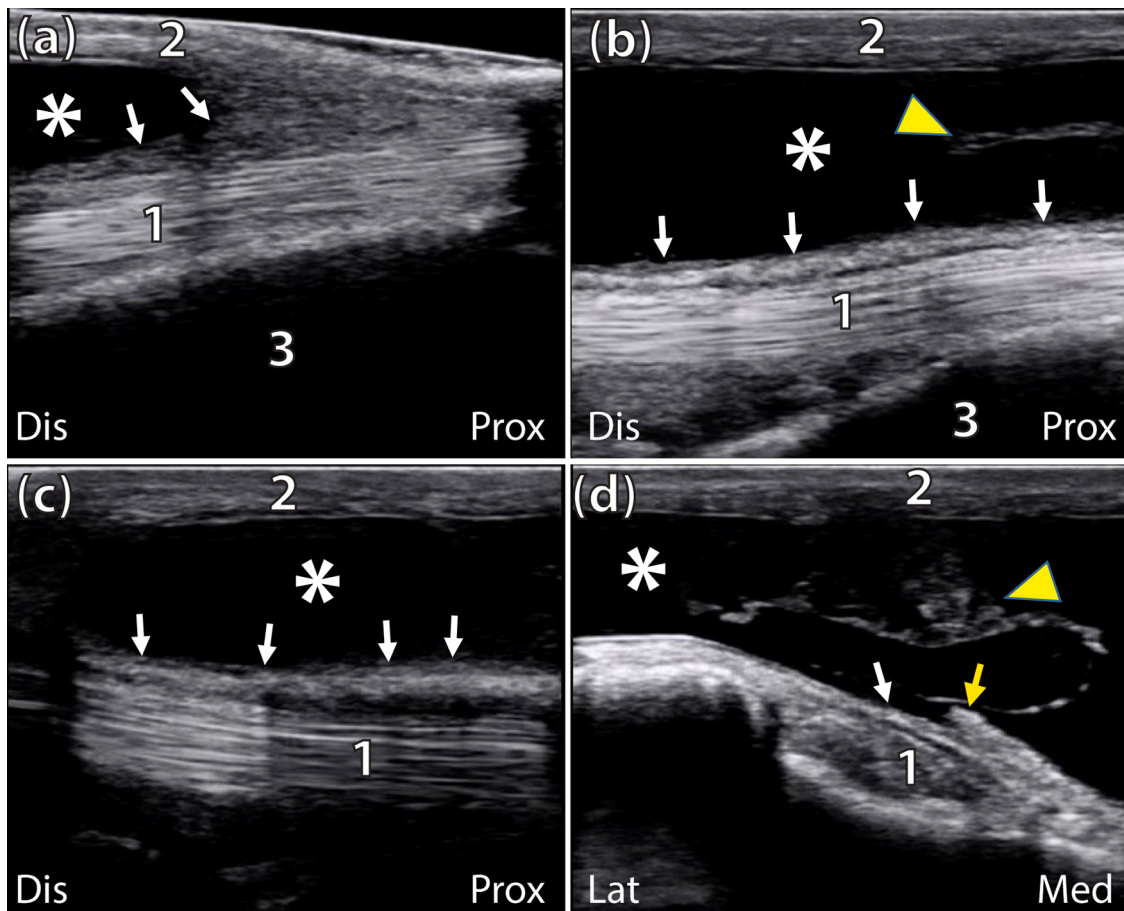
Ultrasonographic appearance of the dorsolateral aspect of the distension on the right carpus. The proximal, medial, and distal areas of the affected region were imaged on the longitudinal (a, b, and c, respectively) and transverse (d) planes. Ultrasonographic imaging demonstrated several structural defects, including a large area of anechoic fluid accumulation (asterisk); fibrous thickening of the inner lining of the tendon sheath adjacent to the common digital extensor tendon (white arrows); synovial cell proliferation (yellow triangles); and persuasive evidence of a torn tendon sheath (yellow arrow). Prox = proximal; Dis = distal; Med = medial; Lat = lateral; 1 = common digital extensor tendon; 2 = skin; 3 = radius.
